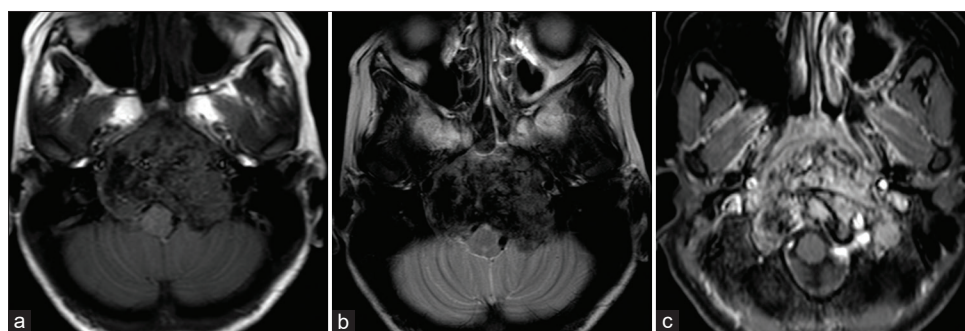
Preoperative magnetic resonance images revealing that the lesion had low intensity on T1- and T2-weighted images. The lesion is enhanced heterogeneously by gadolinium administration. (a) T1-weighted image, (b) T2-weighted image, (c) gadolinium-enhanced image
